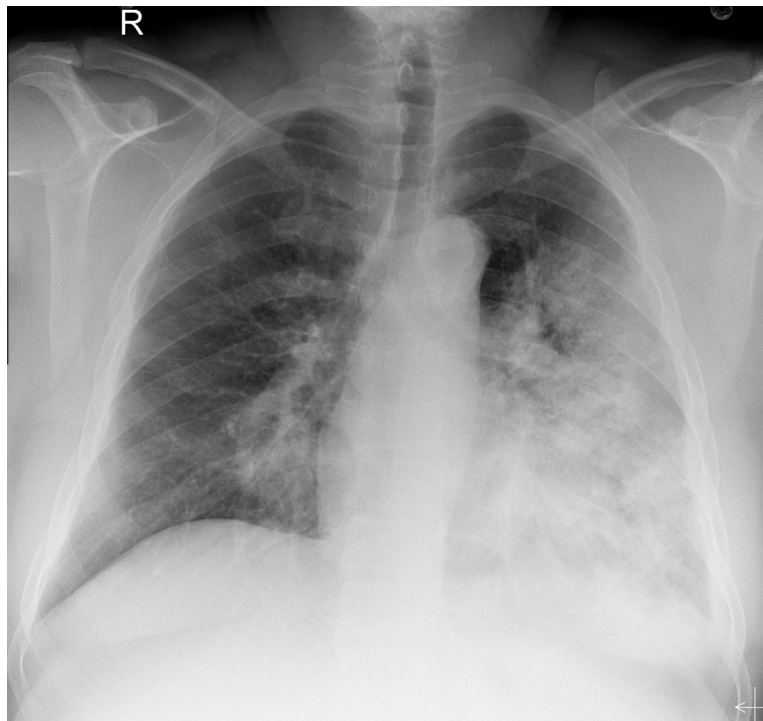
A case of MERS-CoV; Chest X-ray; frontal projection three days after admission showing progression of left lung opacity with extension into the left mid-zone and subtle right paracardiac opacity.
